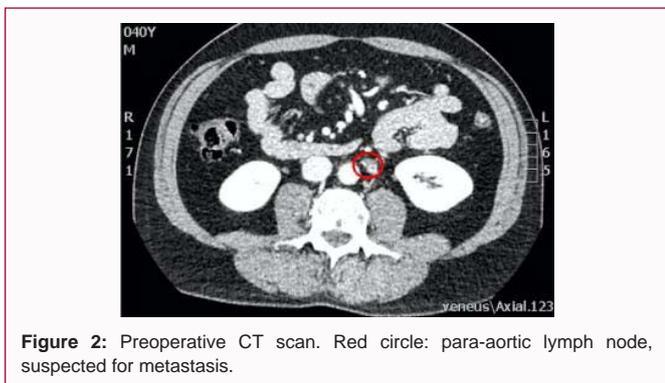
Preoperative CT scan. Red circle: para-aortic lymph node, suspected for metastasis.
